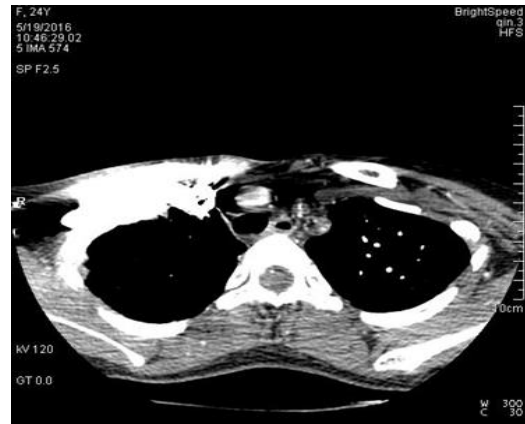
CT angiogram revealed a saccular aneurysm of Aorta and pulmonary artery with thrombosis of left subclavian artery and short segment of right common carotid artery
